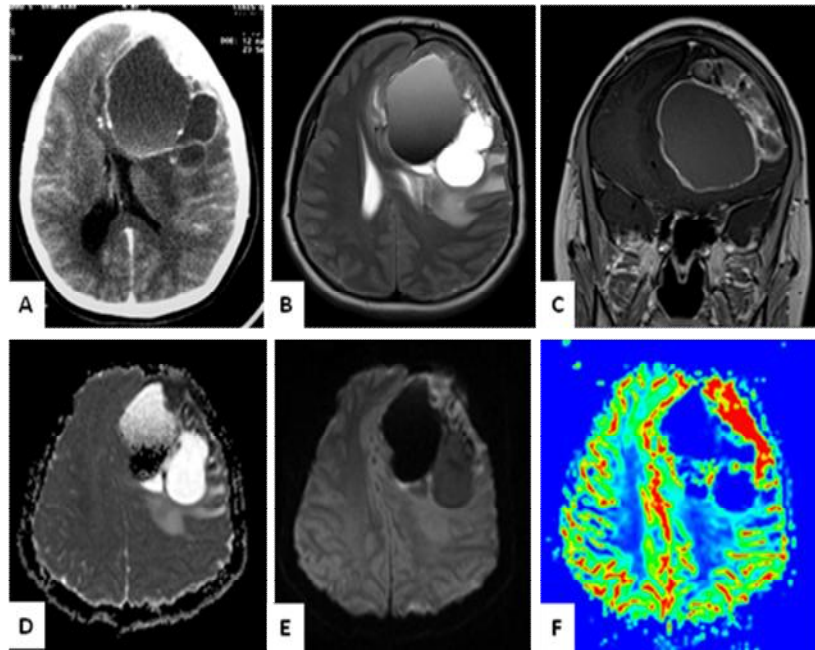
A, cranial axial computed tomography with contrast enhancement shows a left frontal large multicystic mass with peripheral enhancement. B, A, axial T2-WI displays an heterogeneous signal of this lesion. The largest cystic component appeared hypointense whereas the solid component appeared isointense to grey matter. C, post-enhanced coronal T1-WI revealing an intense and heterogeneous contrast enhancement of the solid component of this intracranial mass. D & E, diffusion-WI shows a hyperintense signal with a corresponding hypointensity on the ADC of the solid portion. F, perfusion-WI showed an increase in relative regional cerebral blood volume in this solid component
